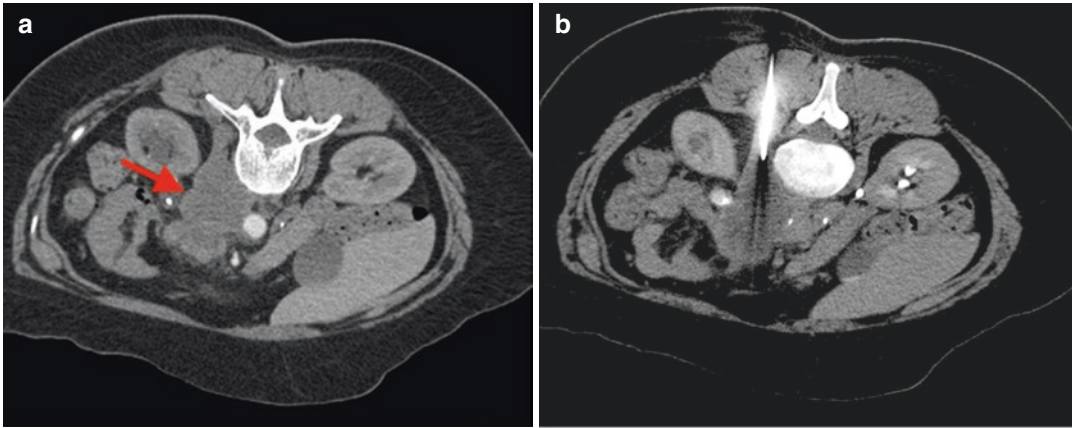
CT-guided percutaneous core-needle biopsy of paraortic conglomerated lymph nodes (a) (arrow). With the patient prone, a core-needle biopsy was performed using a posterior paravertebral approach (b)
